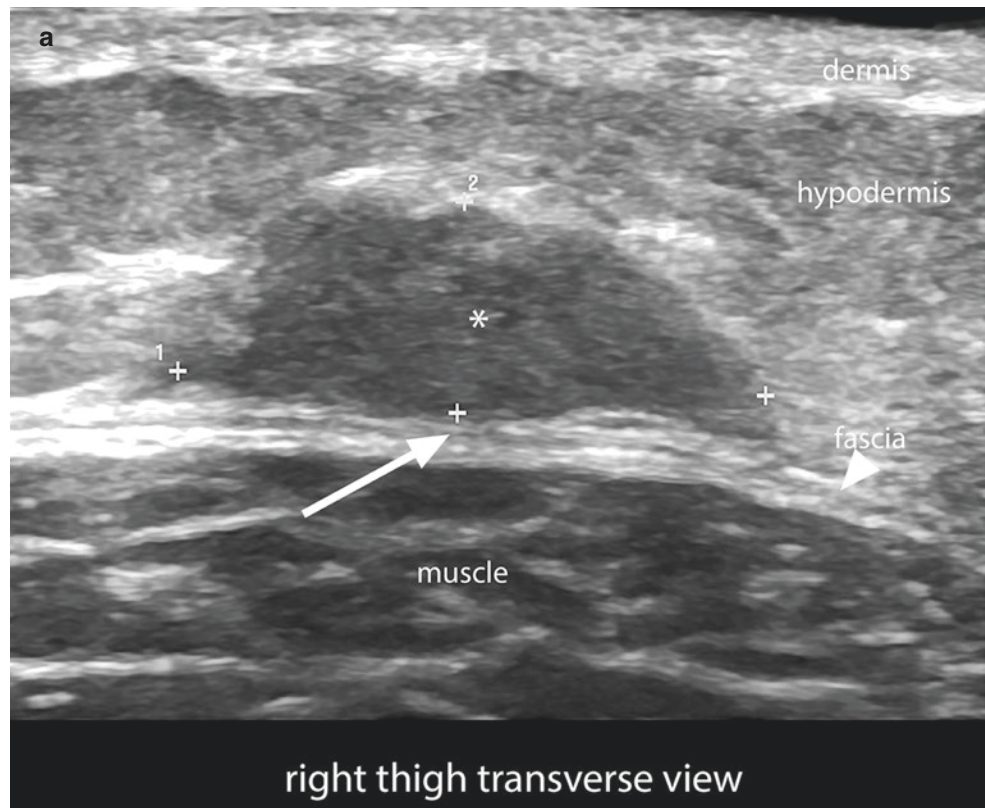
Nodular fasciitis. (a and b), Ultrasound (a, greyscale; b, panoramic view with color filter) shows a hypoechoic nodule in the deep hypodermis, with some irregular contours and attachment to the fascia (arrow). (c) Color Doppler demonstrates increased vascularity in the periphery of the lesion.
